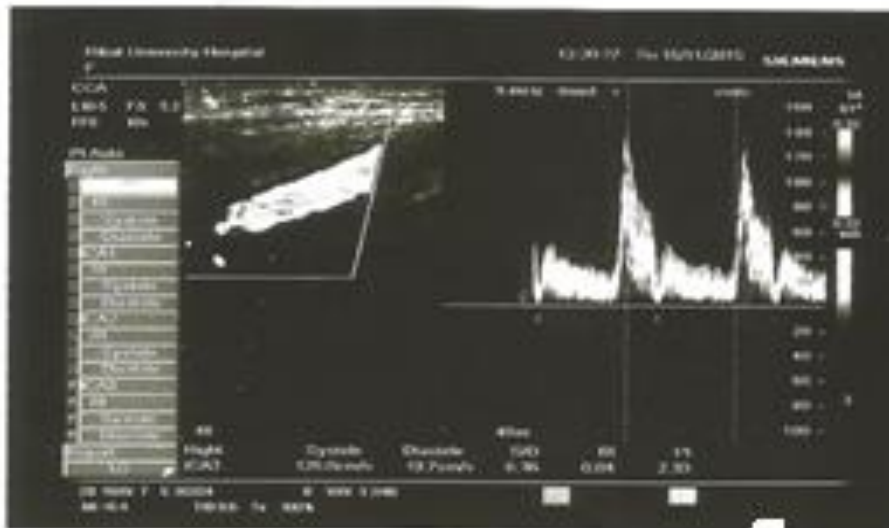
Lt ICA-male- 60 years diabetic patient with normal Doppler parameters.
